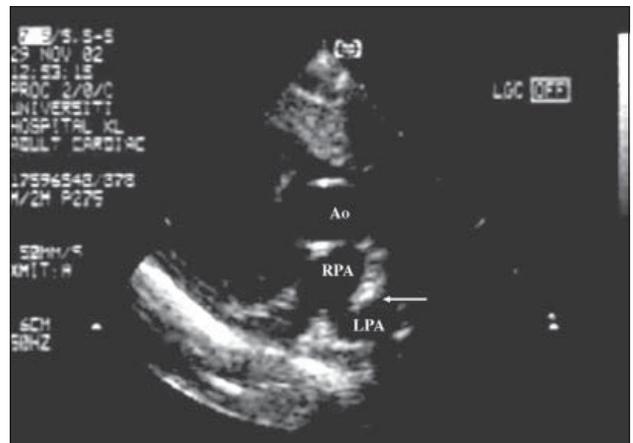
Two-dimensional echocardiogram in the parasternal short axis view showing anomalous origin of the left pulmonary artery (LPA) from the distal right pulmonary artery (RPA), the aorta (Ao), and the trachea (arrow). [Image courtesy of Dr. Zarin Ikmal Zan. Mohd Zain, Department of Paediatrics, University of Malaya Medical Centre.]
